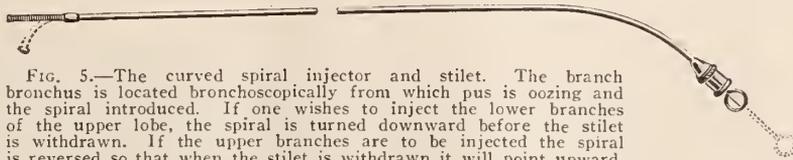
The curved spiral injector and stilet. The branch bronchus is located bronchoscopically from which pus is oozing and the spiral introduced. If one wishes to inject the lower branches of the upper lobe, the spiral is turned downward before the stilet is withdrawn. If the upper branches are to be injected the spiral is reversed so that when the stilet is withdrawn it will point upward. Leakage of the curved spiral may be obviated by applying a coating of flexible collodion to it. The collodion should be thoroughly dry before introduction of the spiral. This will prevent leakage and thereby overcome misinterpretation of the radiographic picture.
